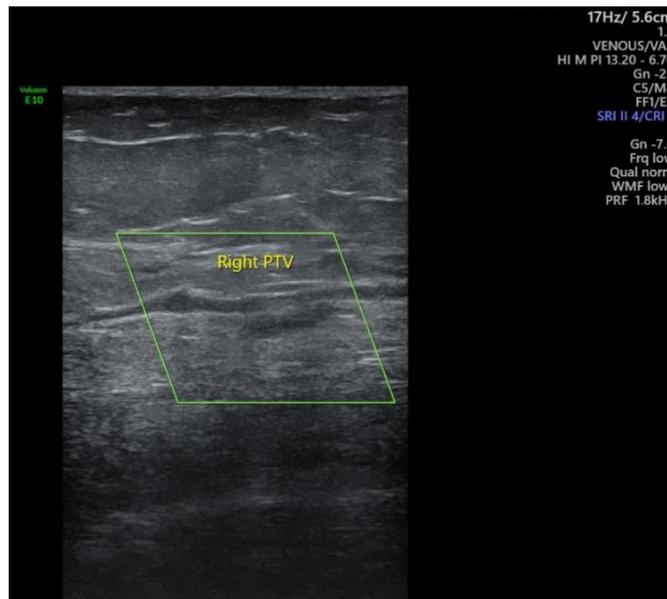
Doppler study of both lower limbs revealed Deep vein thrombosis in right popliteal and posterior tibial veins along with mild subcutaneous edema in both distal legs.
